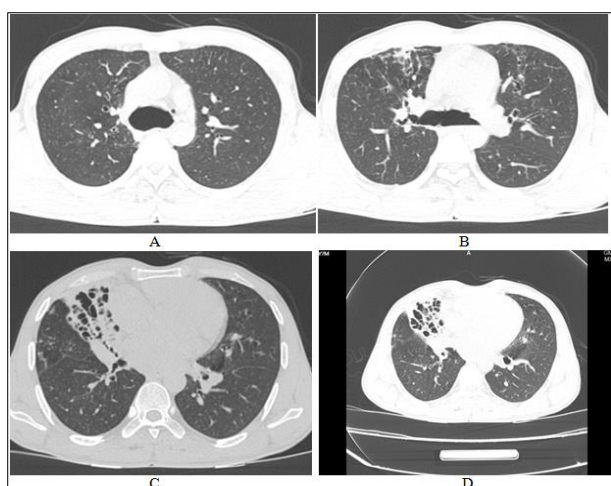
Axial HRCT thorax images in A & B showing dilated trachea and bronchi. C & D showing traction bronchiectasis in right middle lobe.
